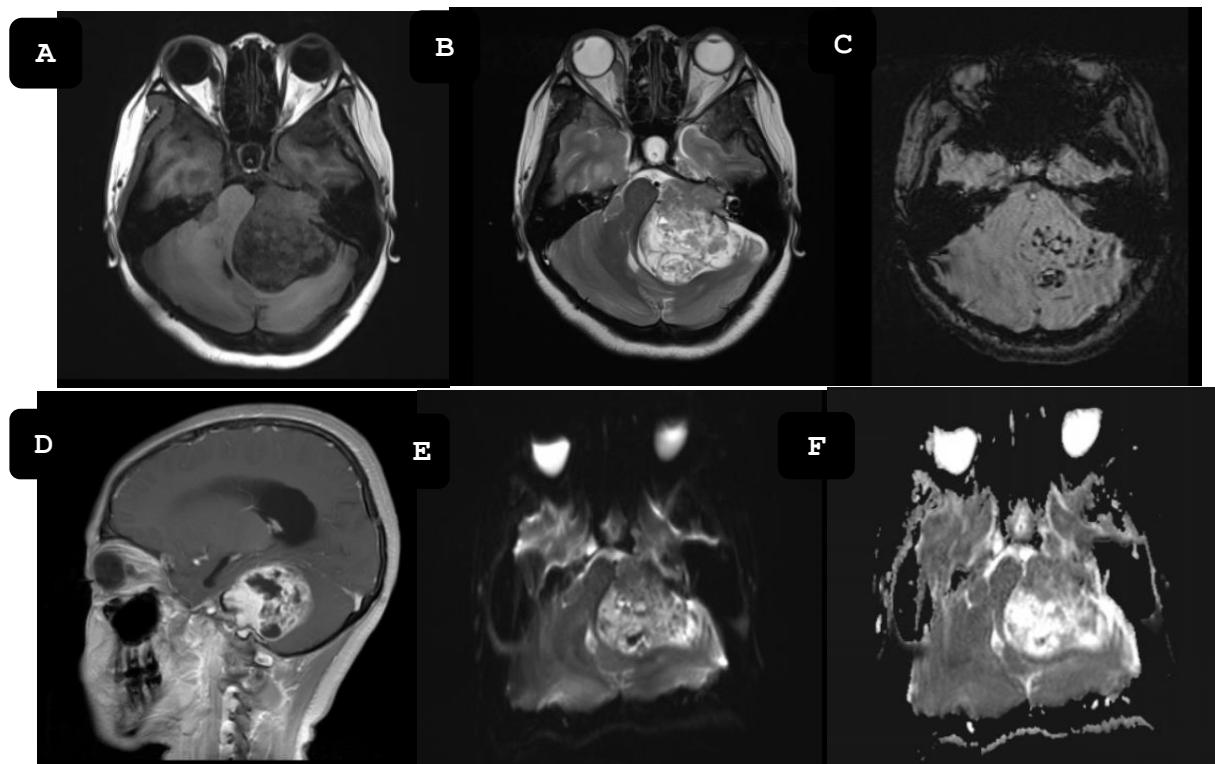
MRI showed hypointense cerebellopontine angle mass in T1WI (A), isointense mass in T2WI (B), blooming artifacts in SWI (C), T1+ Contrast showed enhanced mass (D), No restricted areas diffusion weighted imaging (E and F).
